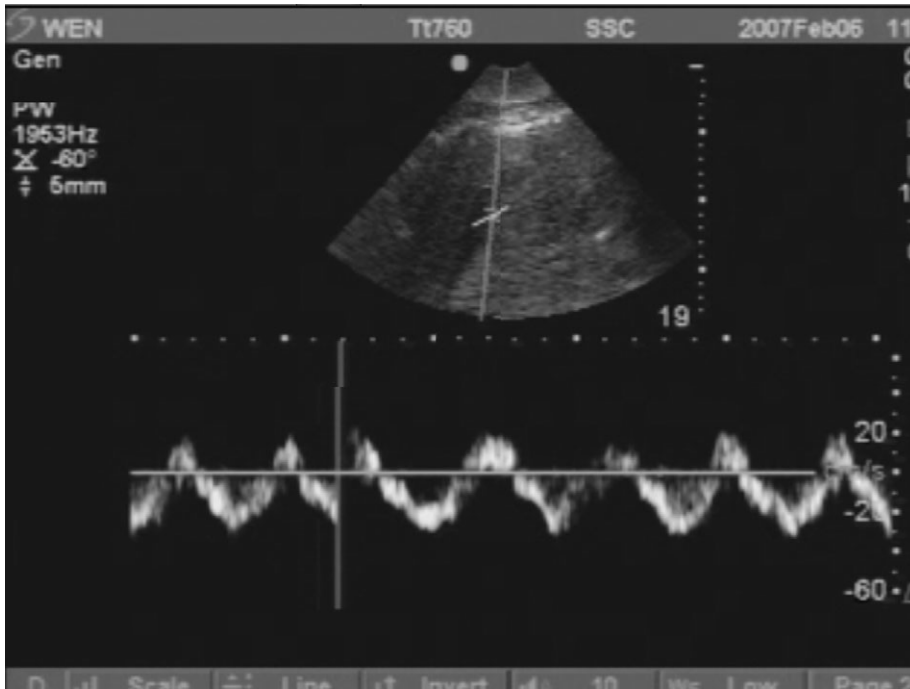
Pulsed-wave Doppler ultrasound acquired from the descending portal vein following 10 dives to a depth of 70 m. The spectral trace in the lower portion of the image demonstrates the velocity of blood flow through the portal vein. Blood flow velocity is measured in cm s^{-1} .
